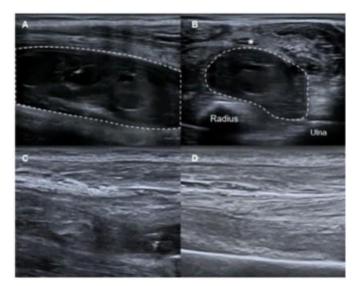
Ultrasound examination revealed a a polycystic hematoma in theflexoroftheforearm(LongAxissectionofhematoma,A). Thehematoma was located between median nerve (*), radius and ulna (ShortAxis sectionofhematoma,B). Threedaysafterdrainageandurokinaselavage, ultrasonography showed that the hematoma had nearly disappeared (C). Hematoma did not recur at the 4-month follow-up after treatment (D).
